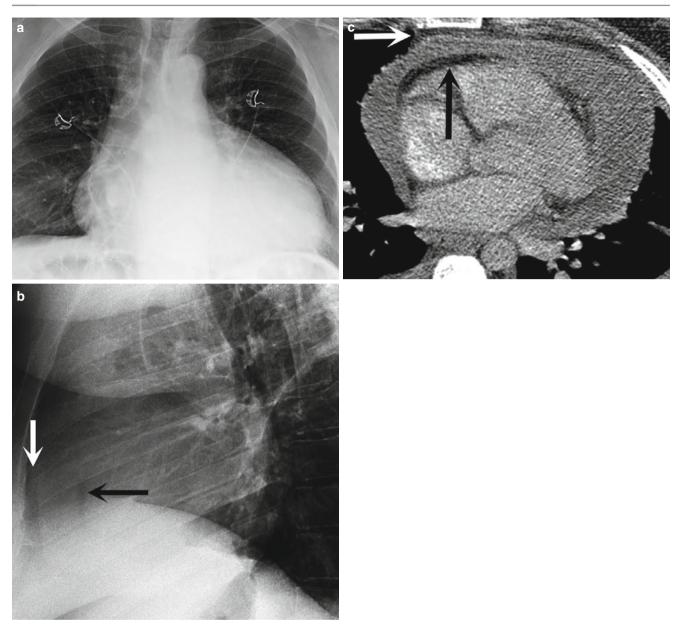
Pericardial effusion in a man with invasive thymic carcinoma. (a) PA radiograph shows global cardiomegaly with obscuration of the hilar structures. (b) The lateral view shows the "fat pad or Oreo
